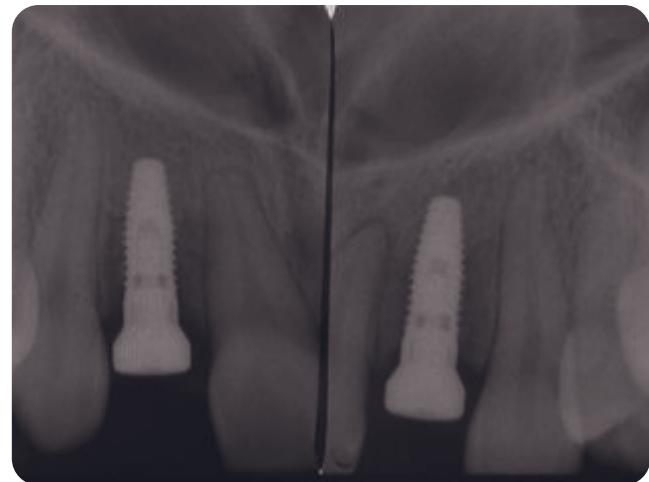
Posttreatment radiographs of integrated implants.
